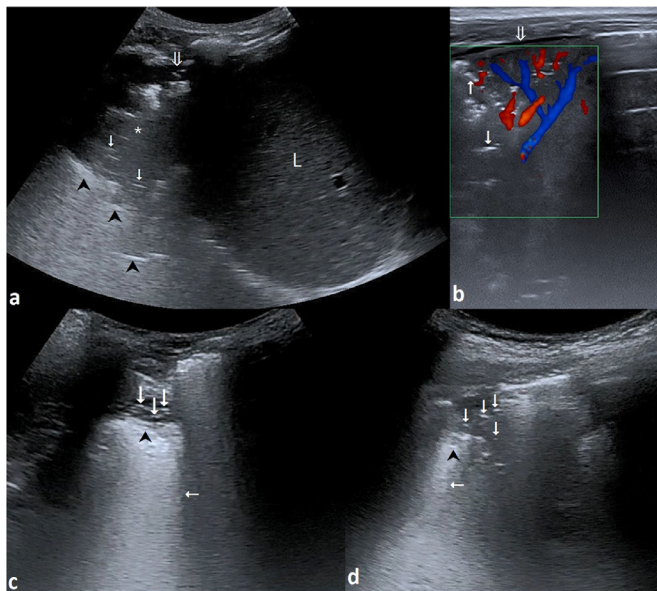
Sonographic features of consolidations.
